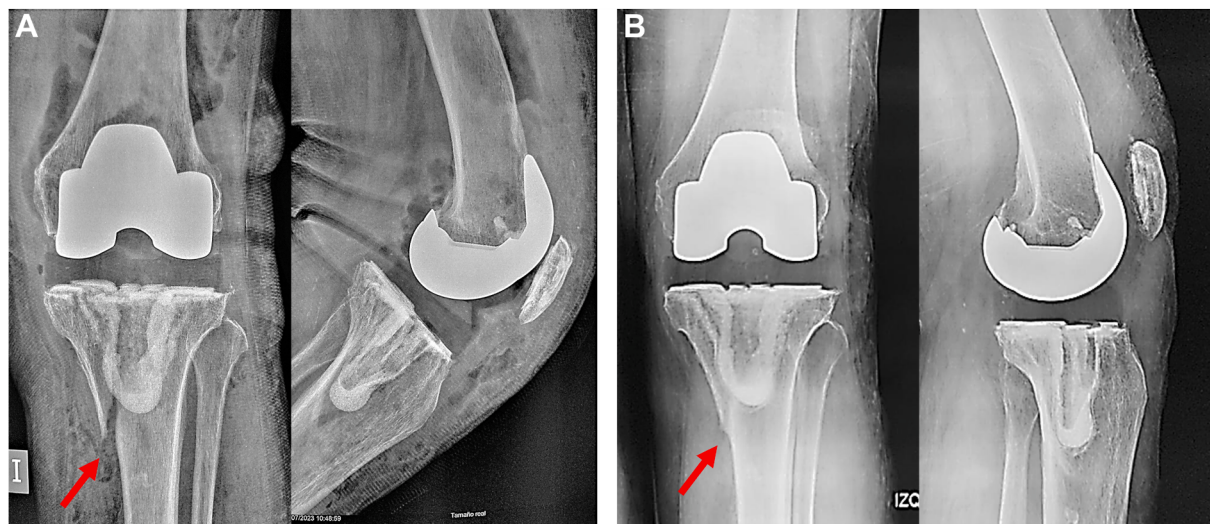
Radiographic evolution of an intraoperative fracture managed successfully within the Hagámoslo Juntos Foundation program. (A) Immediate postoperative antero-posterior and lateral radiographs demonstrating an intraoperative proximal tibia fracture (red arrow). (B) Two-year follow-up antero-posterior and lateral radiographs showing fracture healing (red arrow) with maintained alignment and stable prosthetic components.
